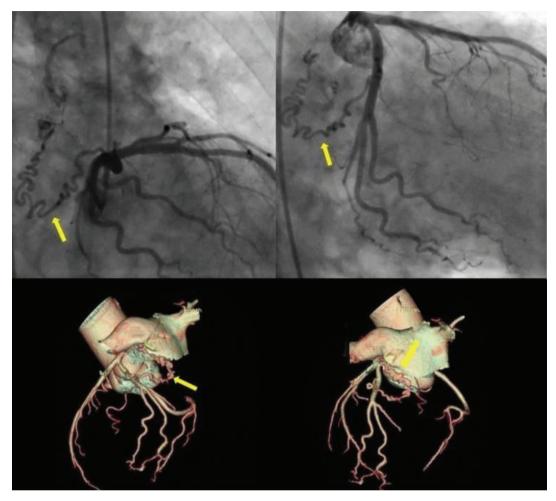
CAG and multislice CT images of the CAF between the Cx artery and the opening of the LIPV into the left atrial cavity CAG: Coronary angiography, CT: Computed tomography, CAF: Coronary artery fistula, Cx: Circumflex, LIPV: Left inferior pulmonary vein
